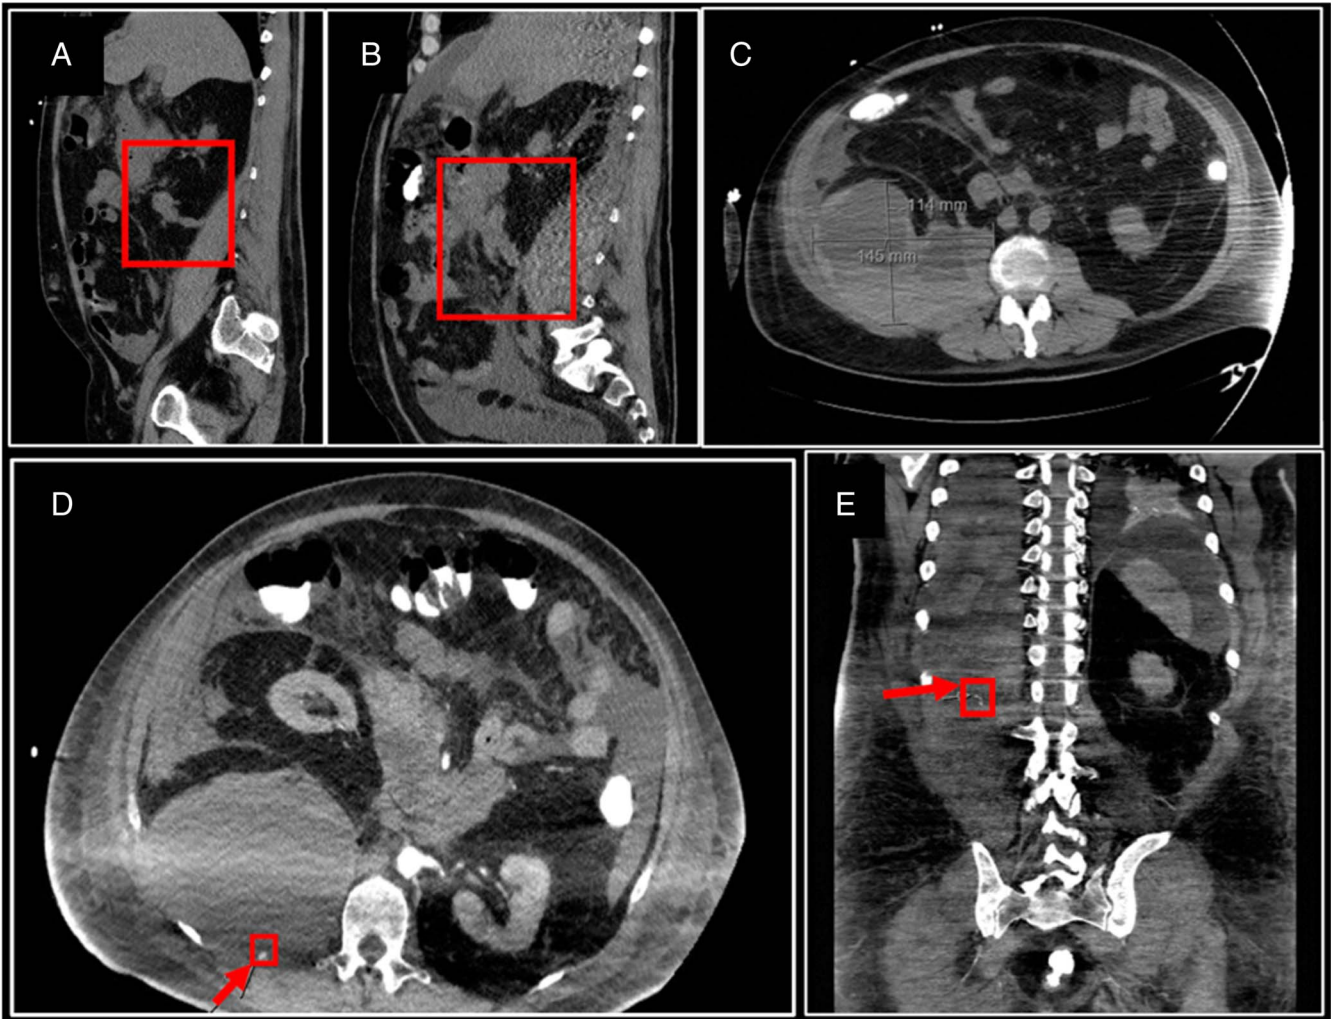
(A) Noncontrast CT before admission identifying early inferoposterior extension of peripancreatic inflammation. (B, C) Noncontrast CT during admission, 4 days before EUS, identifying further inferoposterior extension near iliopsoas muscles and a 14.5 × 11.4 cm retroperitoneal hematoma. (D, E) CT angiography showing a focus of linear serpiginous arterial contrast in the upper aspect of the retroperitoneal hematoma, suspicious for active arterial bleeding. The splenic and gastroduodenal arteries were patent, with no evidence of active hemorrhage or pseudoaneurysm. The red squares highlight the inferoposterior extension of the peripancreatic inflammation (A, B). The red squares were used to show the sites of active arterial bleeding (D, E). CT, computed tomography; EUS, endoscopic ultrasound.
